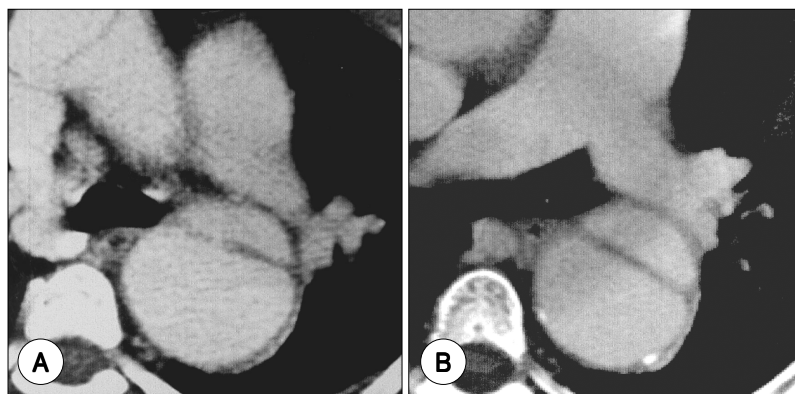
Morphologic change of aorta in patients with residual dissection after surgical correction of intimal tear at long term follow-up. A : CT angiography of 52 year-old-female, one month after aorta surgery for type A aortic dissection, B : not significant interval changes were noted at 35 months later.
